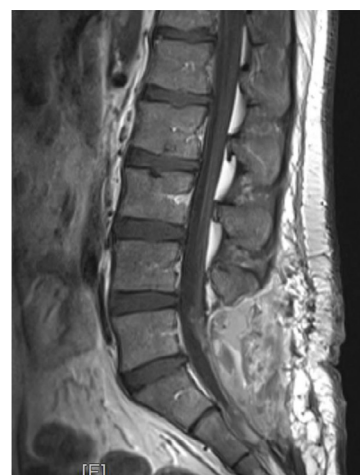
Postoperative MRI showing complete removal of the lesion.
